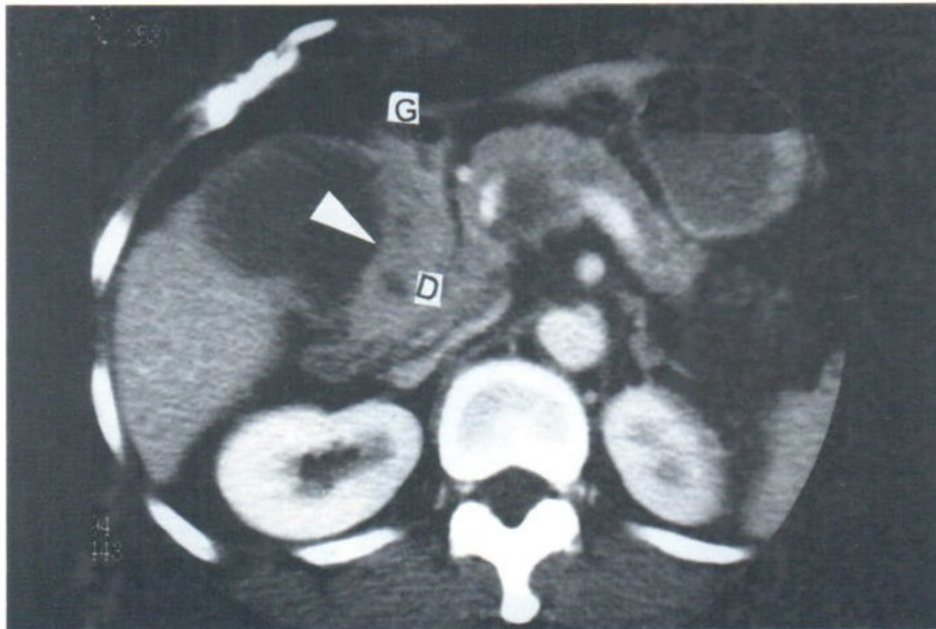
Papillo-tubular adenocarcinoma : CT scan upper abdomen post contrast enhancement of female 57 years old showed enhancing polypoid mass with focal gall bladder wall thickening (arrow). Invasions of the mass to gastric antrum (G) and duodenum (D) were observed by obliteration of the fat plane between them.
